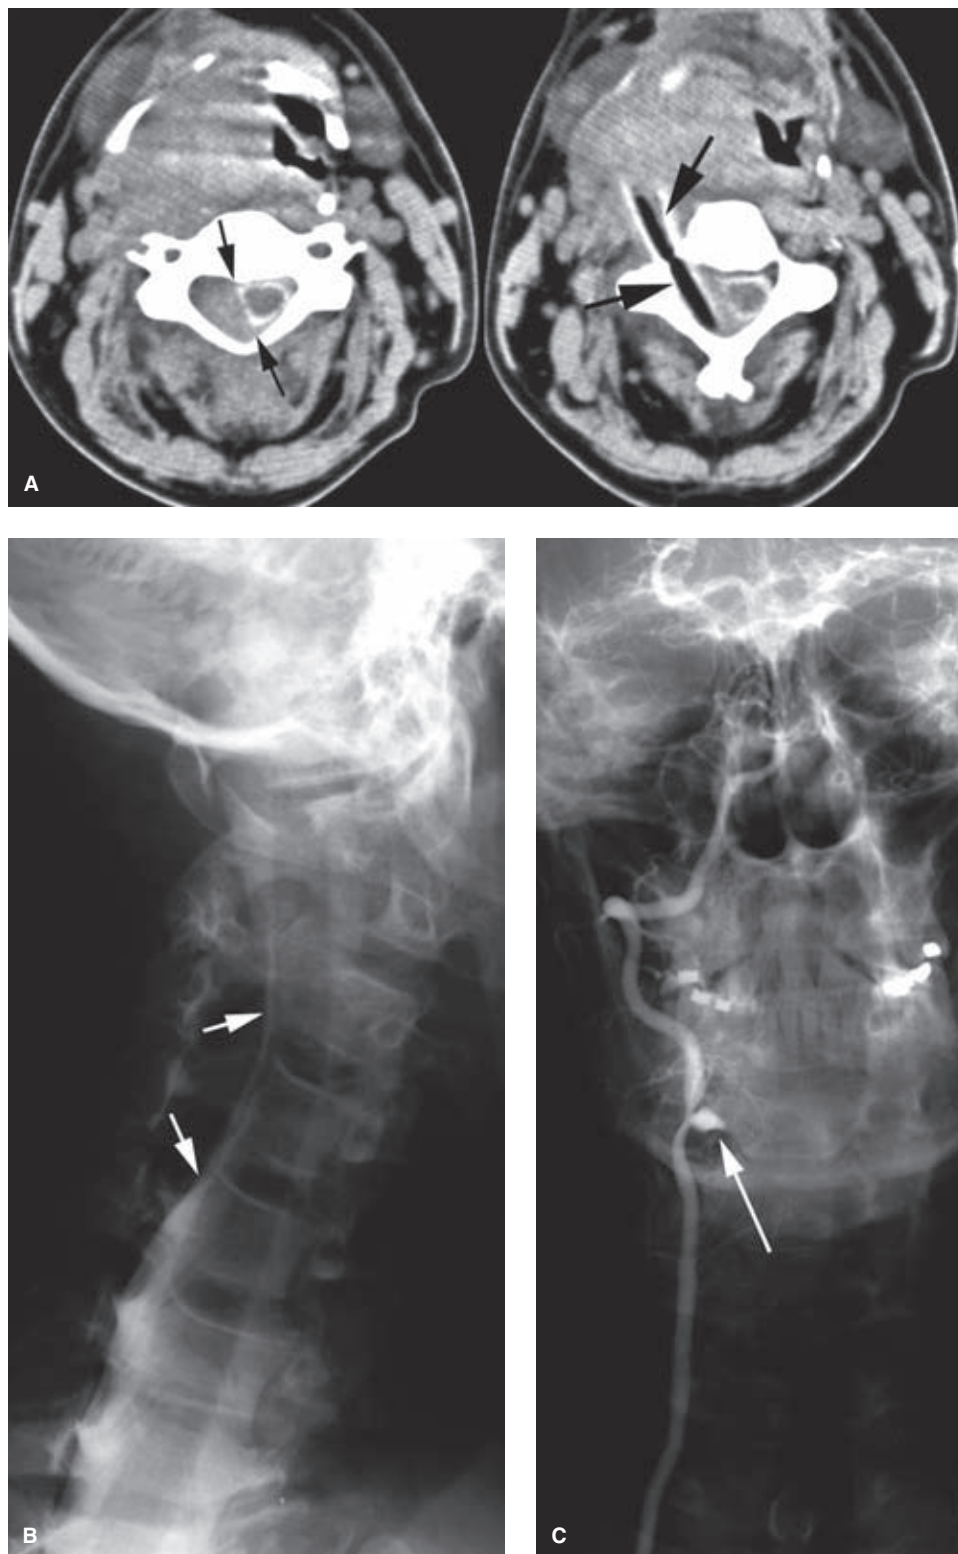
(A–C) Pseudoaneurysm of the right vertebral artery due to wooden foreign body. A: CT myelographic images in a middle-aged patient with a history of a fall on deck lumber. A soft tissue mass representing an infected hematoma displaces the airway toward the patient's left. There is soft tissue (hematoma) within the spinal canal displacing the thecal sac (*small arrows*). A linear structure of air density (*larger arrows*) representing a wooden fragment projects directly through the foramen transversarium of C3, narrowly missing the spine. B: Oblique myelographic image demonstrates displacement of the thecal sac by epidural hematoma (*white arrows*). C: A PA angiographic image of the right vertebral artery demonstrates a pseudoaneurysm of the right vertebral artery at the site of the wooden missile (*arrow*). The artery was sacrificed using balloon occlusion before surgical evacuation of the hematoma.
